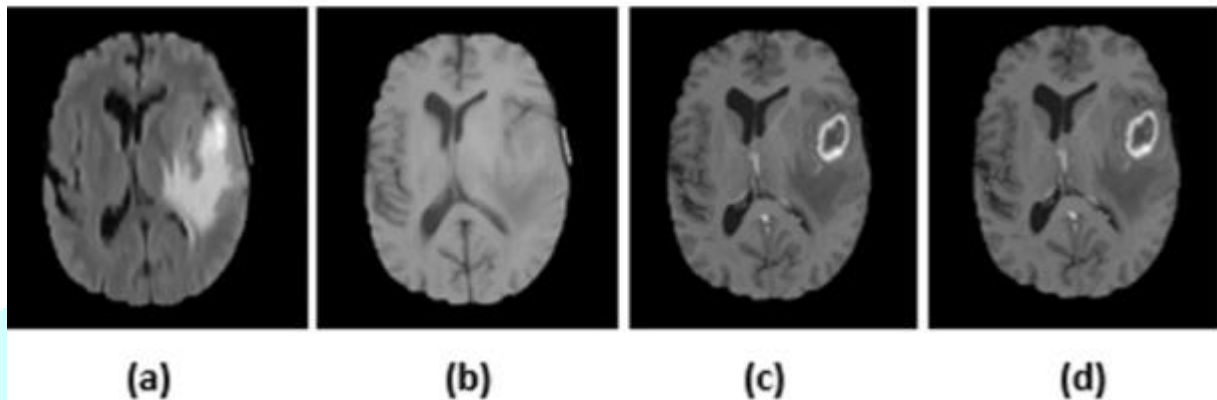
(a) FLAIR (b) T1-w (c) T1-w contrast enhanced (d) T2-w MRI brain Images with HG glioma colle
